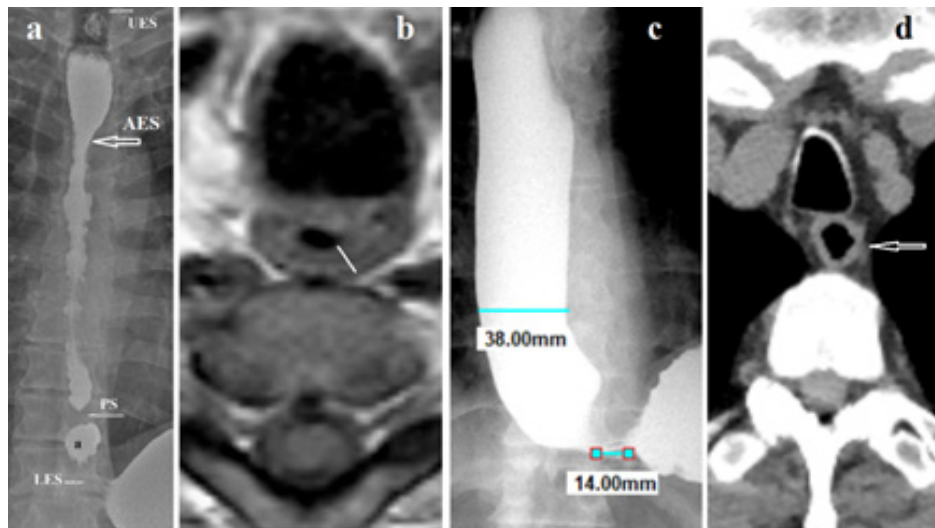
Comparison of radiographic examinations of the esophagus with their image on CT. (a). The patient could eat only liquid food. Belching and vomiting were often observed after meals. He refused to drink milk on the advice of a doctor. Then, immediately after a single intake of a milk drink, severe heartburn occurred, which confirmed lactose intolerance. The length of the LES, from the ampulla to the stomach, is equal to the height of D-10, i.e. about 2 cm, with the minimum normal limit of 3.2 cm. The ampulla is proximally closed by a pathological proximal sphincter (PS). The body of the esophagus from the PS to the aortic arch is in spasm with longitudinal folds and uneven fine-wavy contours. Above the aortic esophageal sphincter (AES), the esophagus dilated. (b). CT of the chest shows thickening of the esophageal wall (white line). (c). A patient with frequent belching and lactose intolerance, which he learned about at the age of 60. The length of the LES 1.4 cm is significantly shorter than the minimum normal limit of 3.2 cm. The esophagus sharply dilated along its entire length. (d). The CT shows a thickened and dense esophageal wall with uneven contours and a deformed perimeter of the ring (arrow). A similar picture observed in all CT sections, indicating fibrous changes in the esophageal wall. In fact, the wide esophagus was a fibrous sac with impaired peristalsis and constant gas throughout the entire length of the esophagus.
